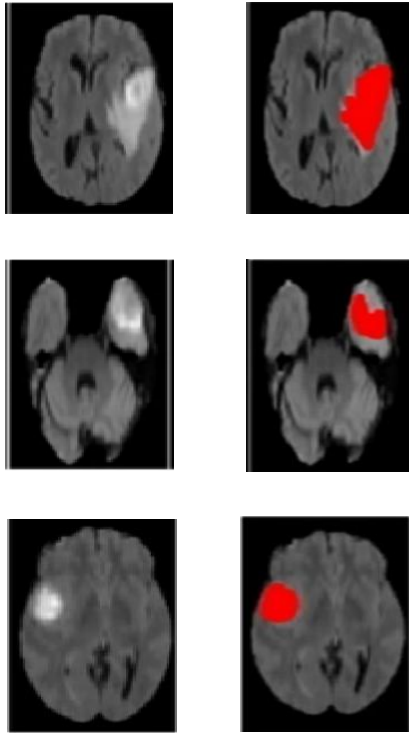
Tumor Segmentation in MRI Images (Left column indicates Original Image and the Right Column indicates Segmented Image)
